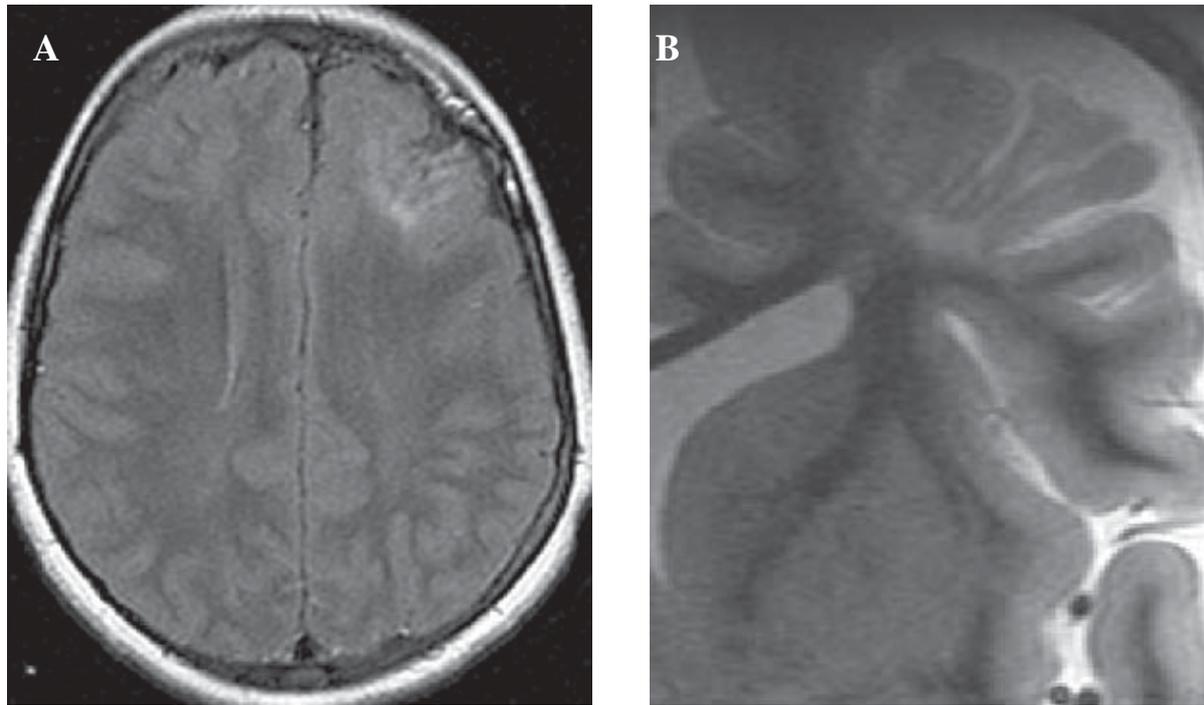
FLAIR axial (A) and high resolution T2 FSE coronal (B) MR scans in a patient with ulegyria.
